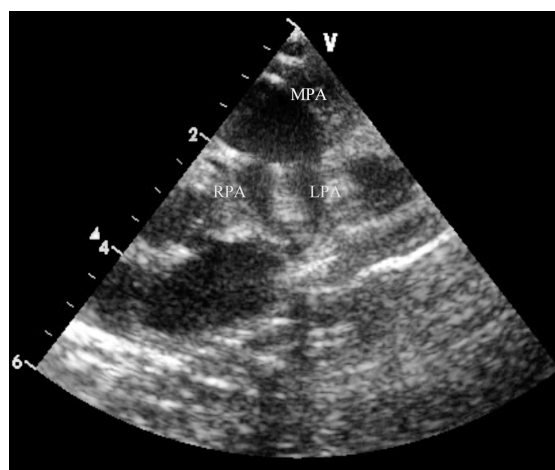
2D echocardiogram (short-axis view) shows a dilated main pulmonary artery. MPA: main pulmonary artery; RPA: right pulmonary artery; LPA: left pulmonary artery
